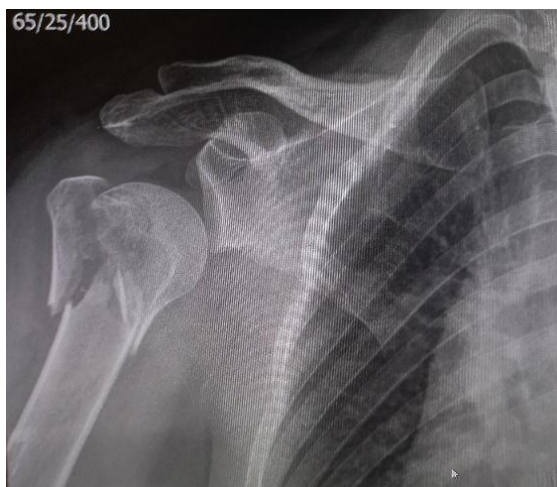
X-ray showing a comminuted fracture of the proximal humerus
